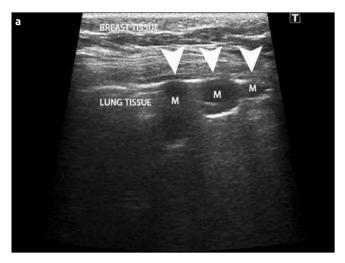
a, b. a) Ultrasonographic examination detected mass lesions compatible with nodular metastasis, which were peripherally localized, adjacent to the visceral pleura and mobile during respiration in the lung parenchymal under the breast tissue (arrowheads). b) Chest X-ray shows a large number of nodular lesions in the both lung.
